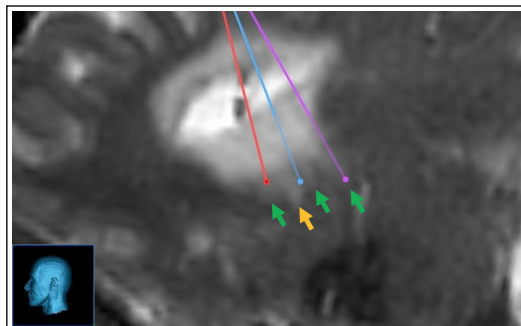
Visualization of cell suspension tracts on T2-weighted MRI. Cell suspension (green arrows) can be differentiated from encephalomalacia (orange arrow) by comparison to preoperative MRI.
